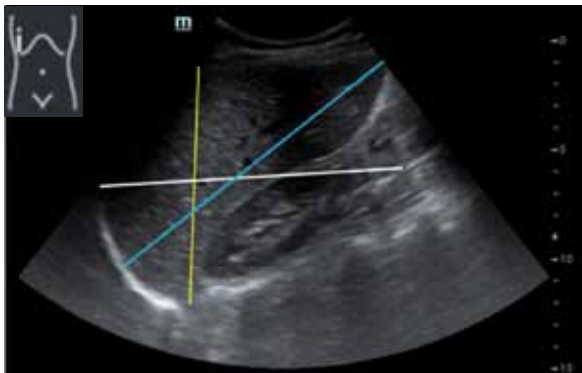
Ultrasound measurements of the right liver lobe in volunteer M., 43 years old. Transducer orientated longitudinally in the VII-X intercostal spaces in the anterior axillary line. Blue color indicates the oblique maximum craniocaudal diameter, white — the craniocaudal diameter, yellow — the anteroposterior diameter
